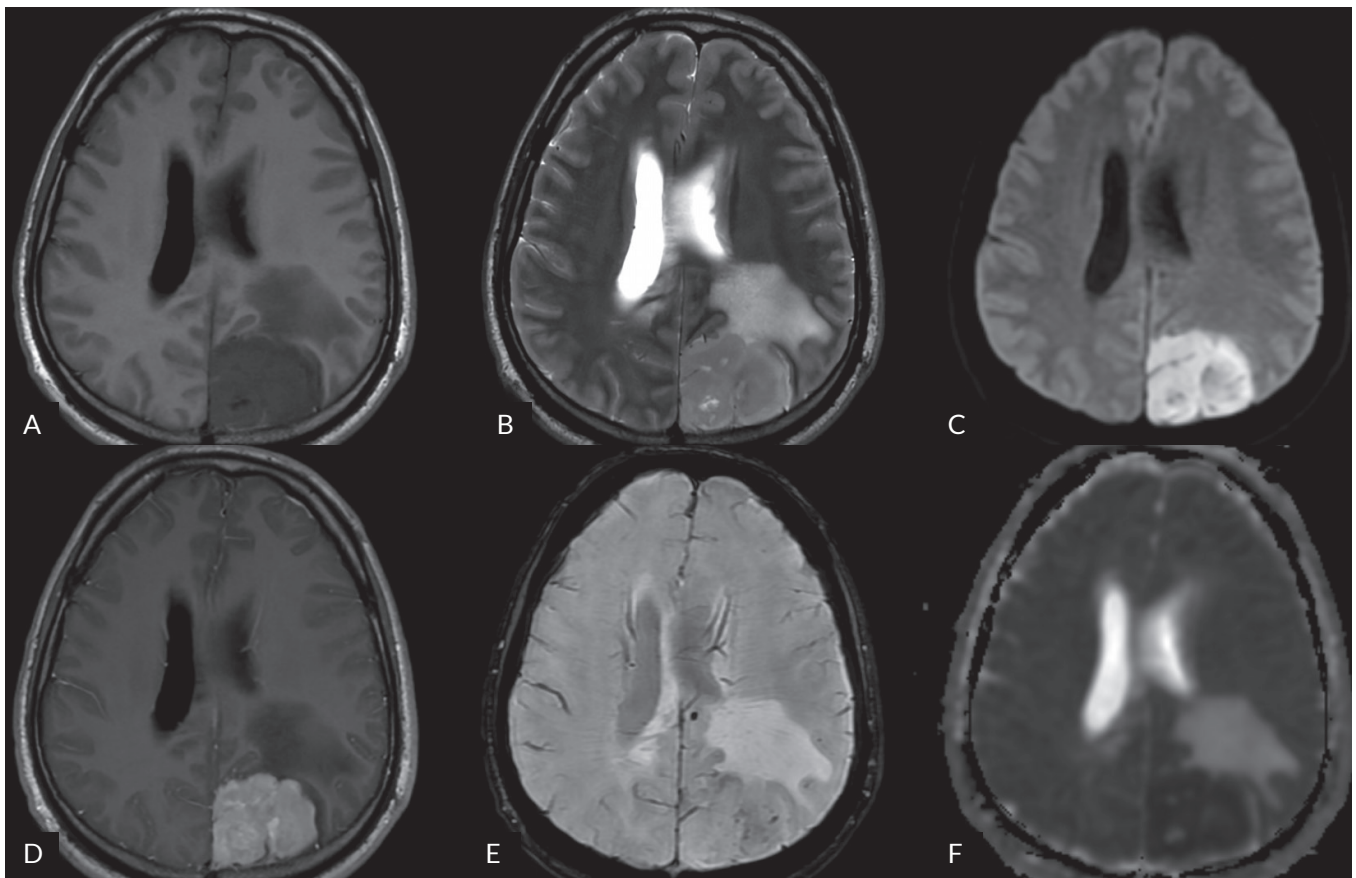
Selected MRI scans of the head, performed during the patient's second admission, show progression in the size of two lymphomas in the left parietal-occipital region, which had already merged into one. Peritumoral oedema is also visible, increased compared to the baseline scan. A. Pre-contrast T1-weighted image. B. T2-weighted image. C. DWI image. D. Post-contrast T1-weighted image. E. SWAN image. F. ADC map
